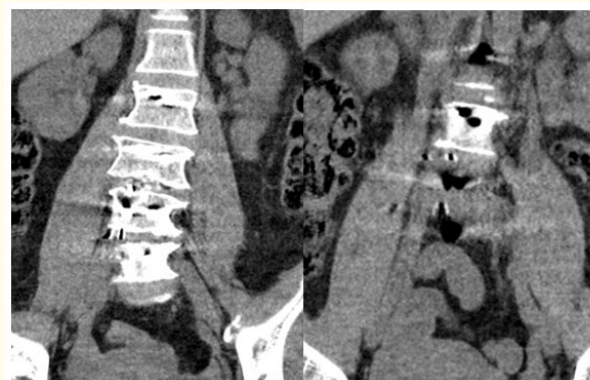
Follow up CT scan after 3 months shows resolving of the psoas hematoma.
